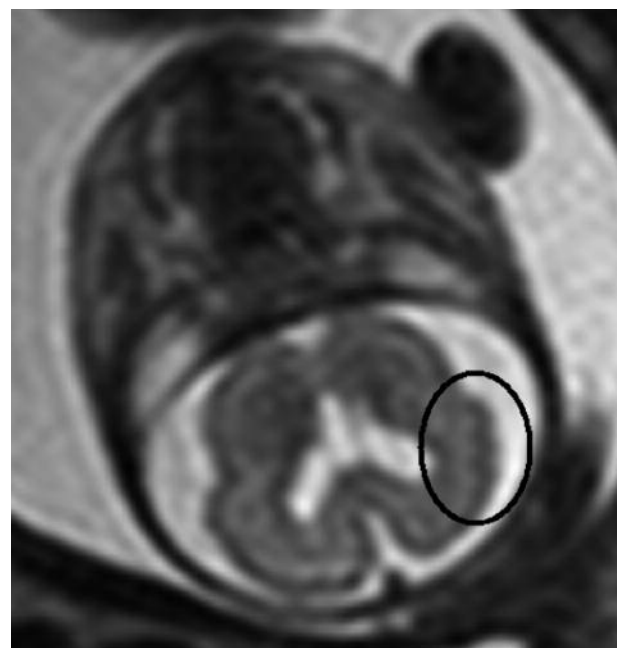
MRI coronal view of polymicrogyria (encircled in black) in a proven congenital CMV infection. Also note the hypoplastic corpus callosum.
